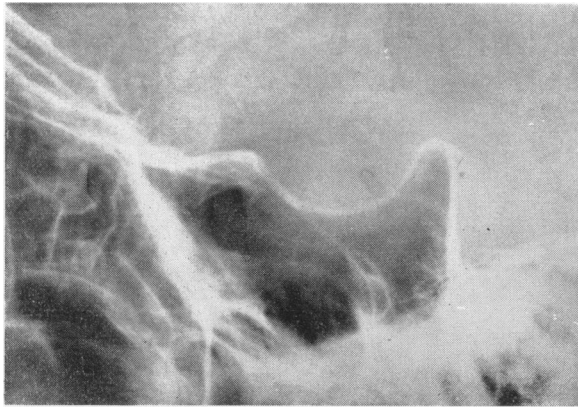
Deceptively small and shallow pituitary fossa containing a surgically verified chromophobe adenoma. (Area enclosed within pituitary fossa in original radiograph was 1.4 sq. cm.—see text.)
